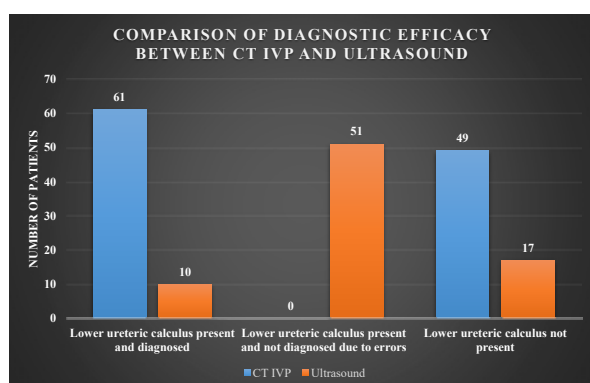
Comparison of Diagnostic Efficacy Between Ultrasound and CT IVP for Lower Ureteric Calculus
